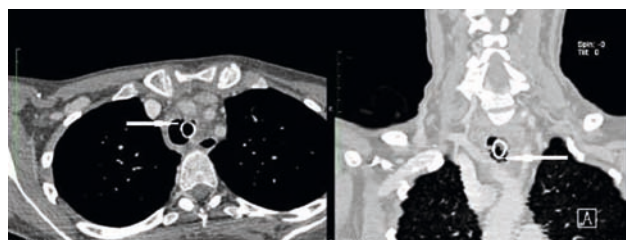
Enhanced CT of thorax and neck indicating close contact between the trachea and the innominate artery (IA) at the level of the tracheostomy cuff, suggesting TIF.
